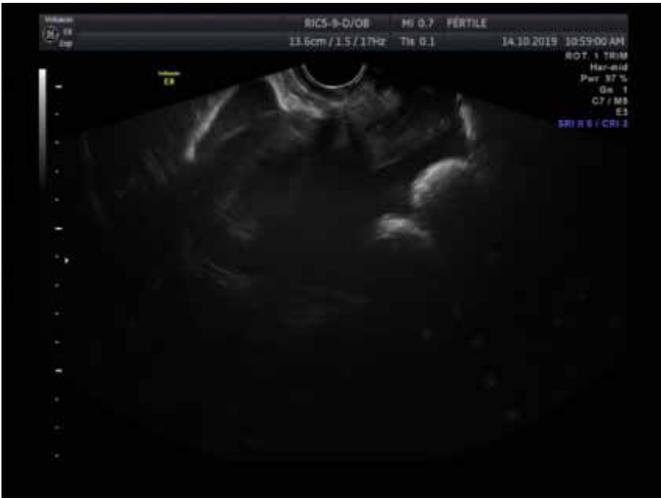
Obstetric ultrasound showing the presence of free fluid in the abdominal cavity
